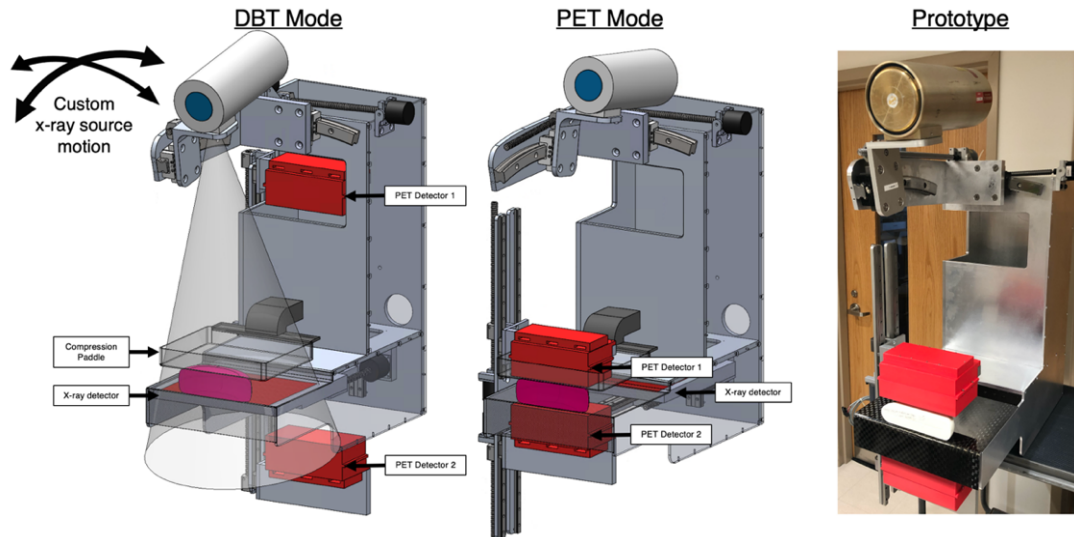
Design and photograph of the PET-DBT prototype. During DBT Mode, x-ray images are acquired while PET detectors are retracted into a homing position. Immediately following a tomosynthesis acquisition, PET detectors are positioned above and under the compressed breast and a PET scan is acquired (PET mode).
